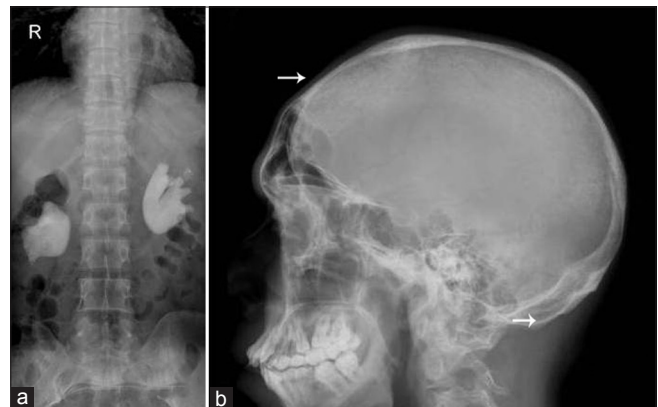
(a) Anterior-posterior radiograph of the lumbar spine showing, bilateral staghorn calculi (arrows). Osteopenia in the vertebrae is also noted. (b) Lateral radiograph of the skull showing granular deossification giving the classical salt and pepper appearance (arrows) and loss of sharp definition of the inner and outer tables
